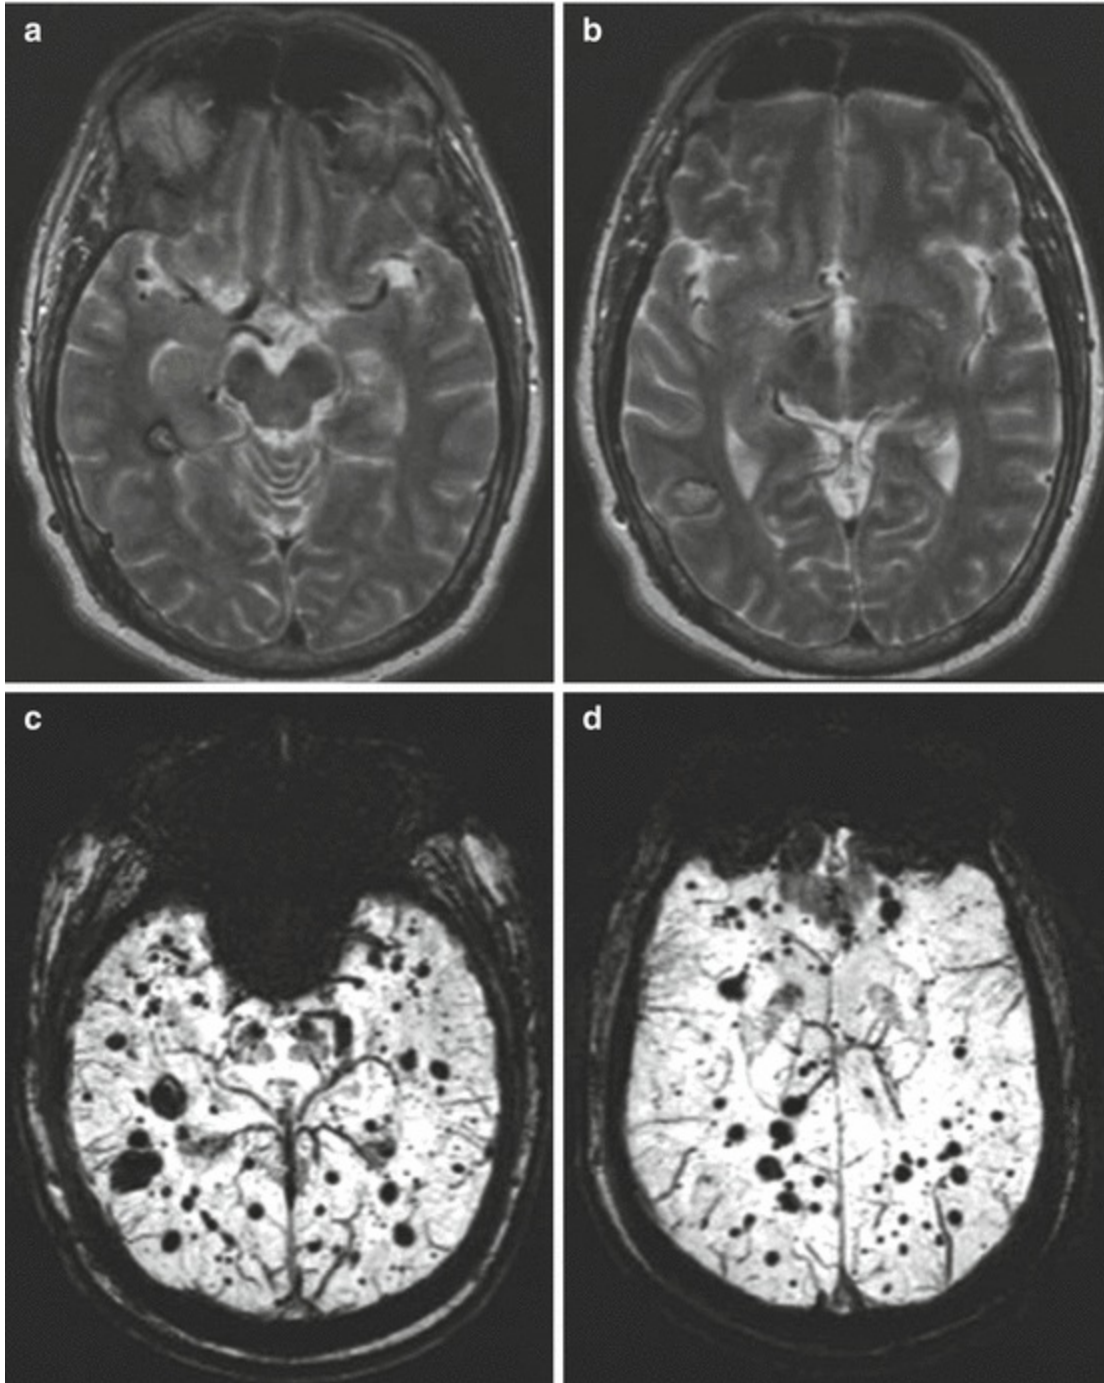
MRI findings in familial cerebral cavernous malformation syndrome. A 57-year-old man with a family history of cavernous malformation (an affected son) presented with a seizure. Axial T2-weighted brain MRI images show (a, b) two cavernous malformations with characteristic lobulated appearance of mixed signal intensities surrounded by a rim of hypointense signal. (c, d) Innumerable foci of abnormal hemosiderin, consistent with prior microhemorrhages, are shown on axial susceptibility-weighted MRI sequences
